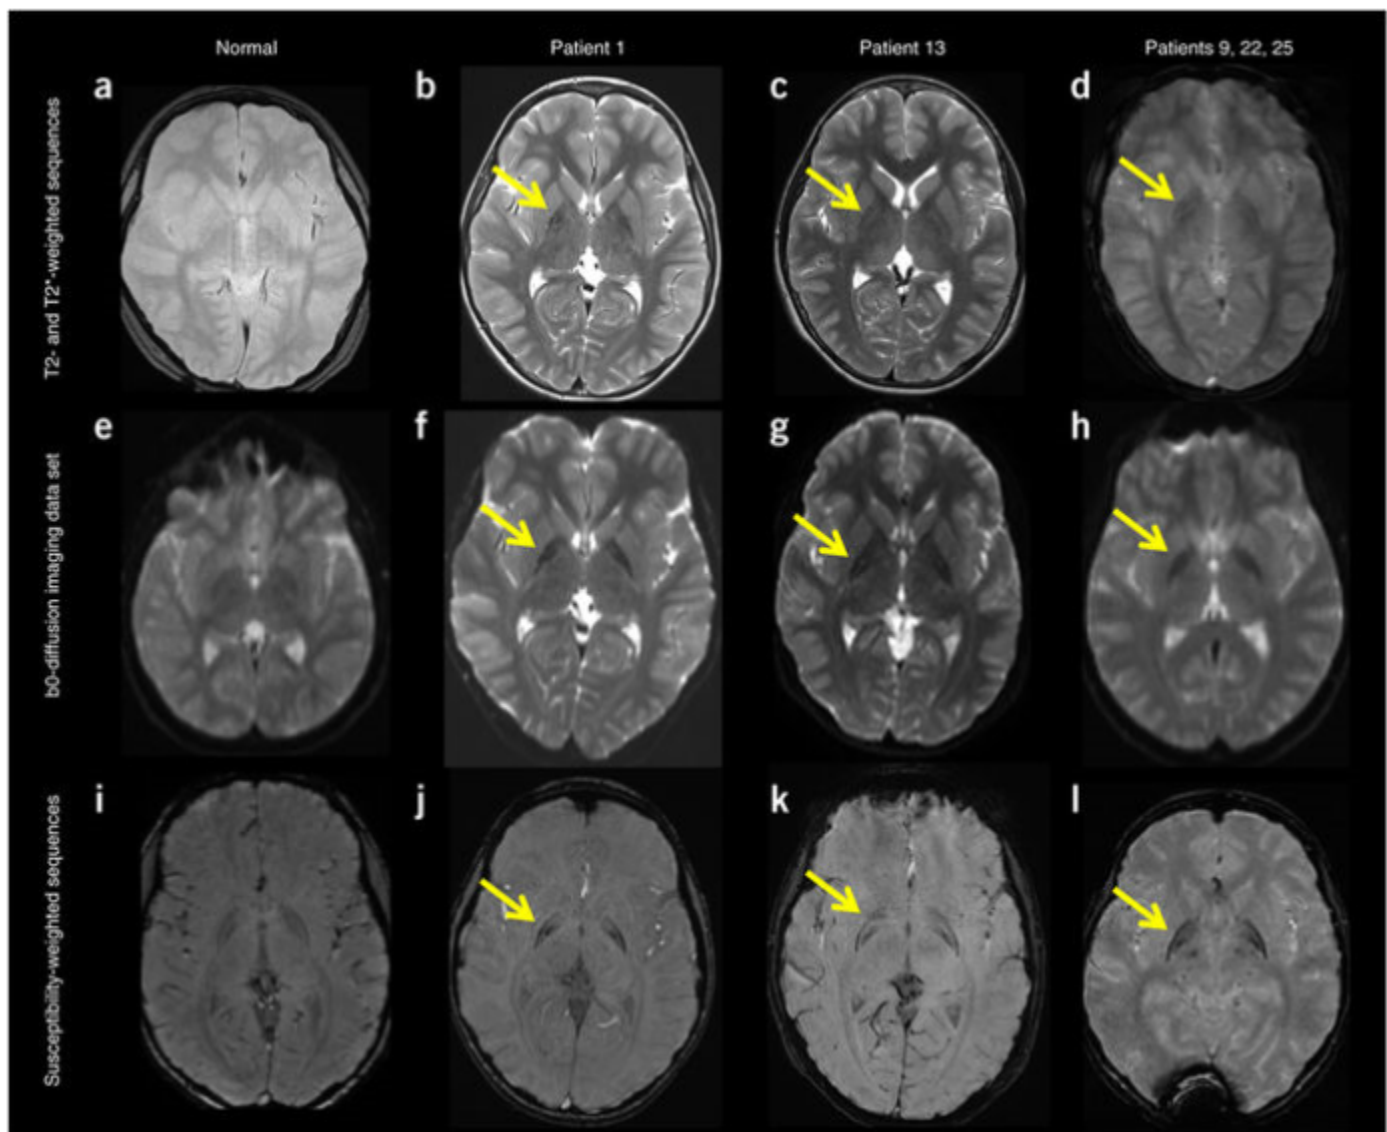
Radiologic MRI features of patients with *KMT2B* variants
